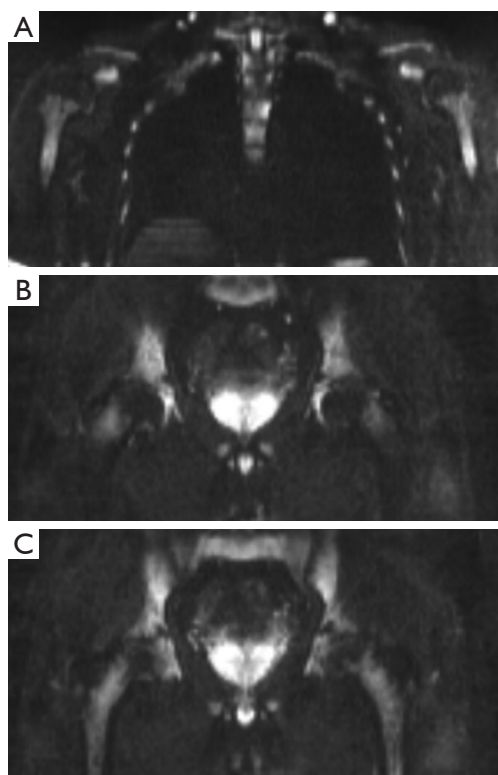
The maximal intensity projection image of the WB-DWI ($b=800$ s/mm²) of a 48-year-old male amateur marathon runner. The bone marrow in the bilateral humeral head (A), femoral head and great trochanter (B,C) was hypointense, while the bone marrow in the metaphysis and proximal of the humerus (A) and femur (B,C) was hyperintense. WB-DWI, whole-body diffusion-weighted imaging.
